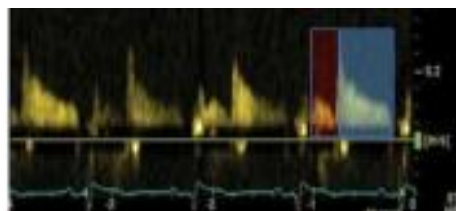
Left coronary doppler pattern. Red. Systolic phase. Blue. Diastolic phase
